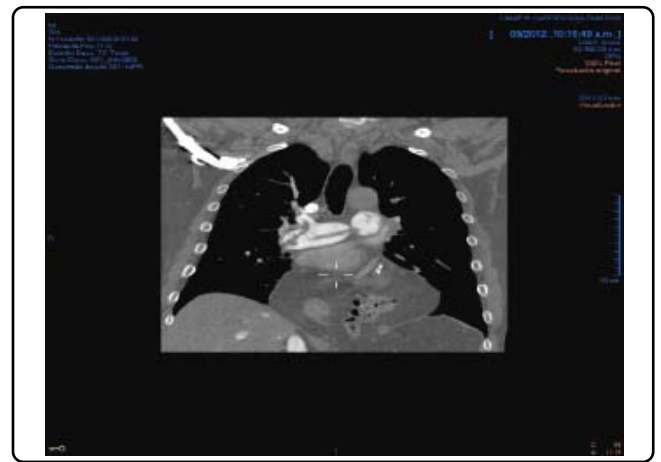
CT coronal scan shows the right and left main pulmonary artery division, there is a linear hipodense image that goes into both artery. This hipodense image is a blood clot. Notice that there is blood clot further into the right side. There is a mottled image over the heart that is a diaphragmatic hernia.
